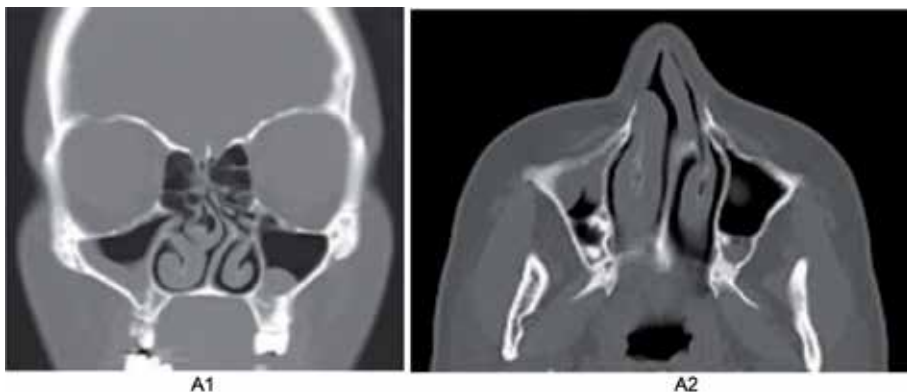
Coronal (A1) and axial (A2) CT scan serial cuts of paranasal sinuses showing a markedly deviated nasal septum with pneumatized diseased right middle turbinate and evidence of sinusitis.
